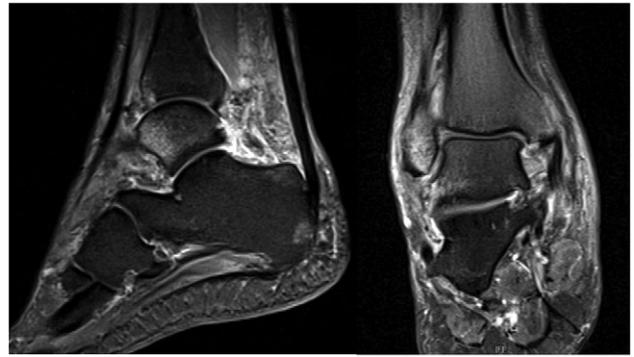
T2 MRI images showing high signal in medial malleolus, lateral malleolus and talus signifying bone bruise.
